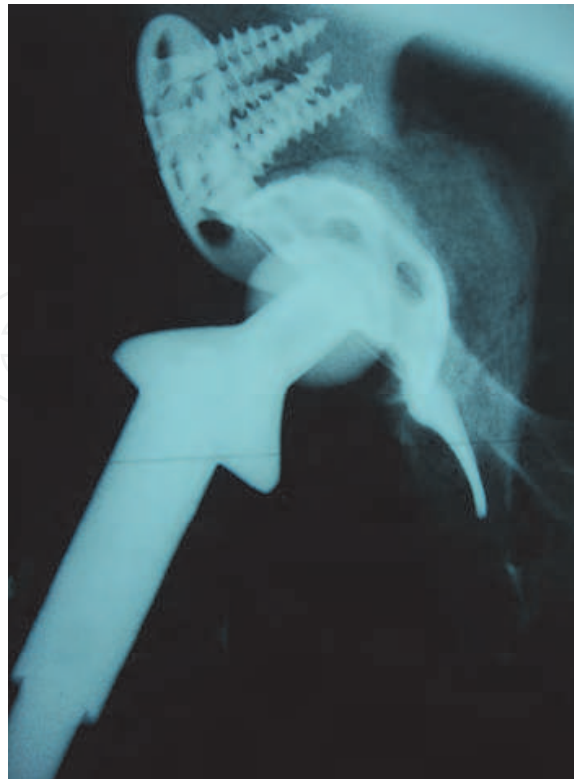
The same patient after revision THA on lateral radiograph. Note massive autologous bone grafts under the Bursch-Schneider ring.
